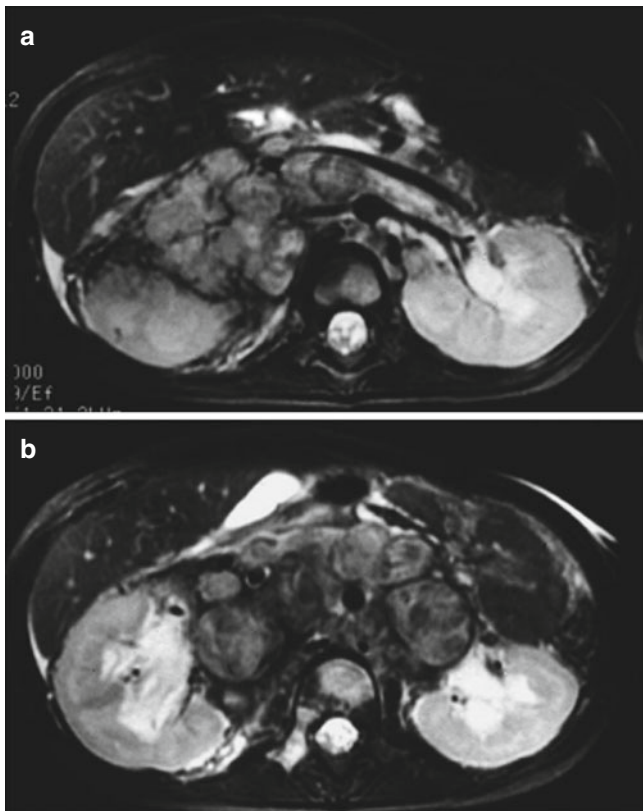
(a, b) Axial weighted MRI demonstrating right adrenal mass with bulky, conglomerate adenopathy encasing the bilateral renal vessels and aorta. Bone marrow involvement is seen in the right posterior vertebral element and vertebral body
